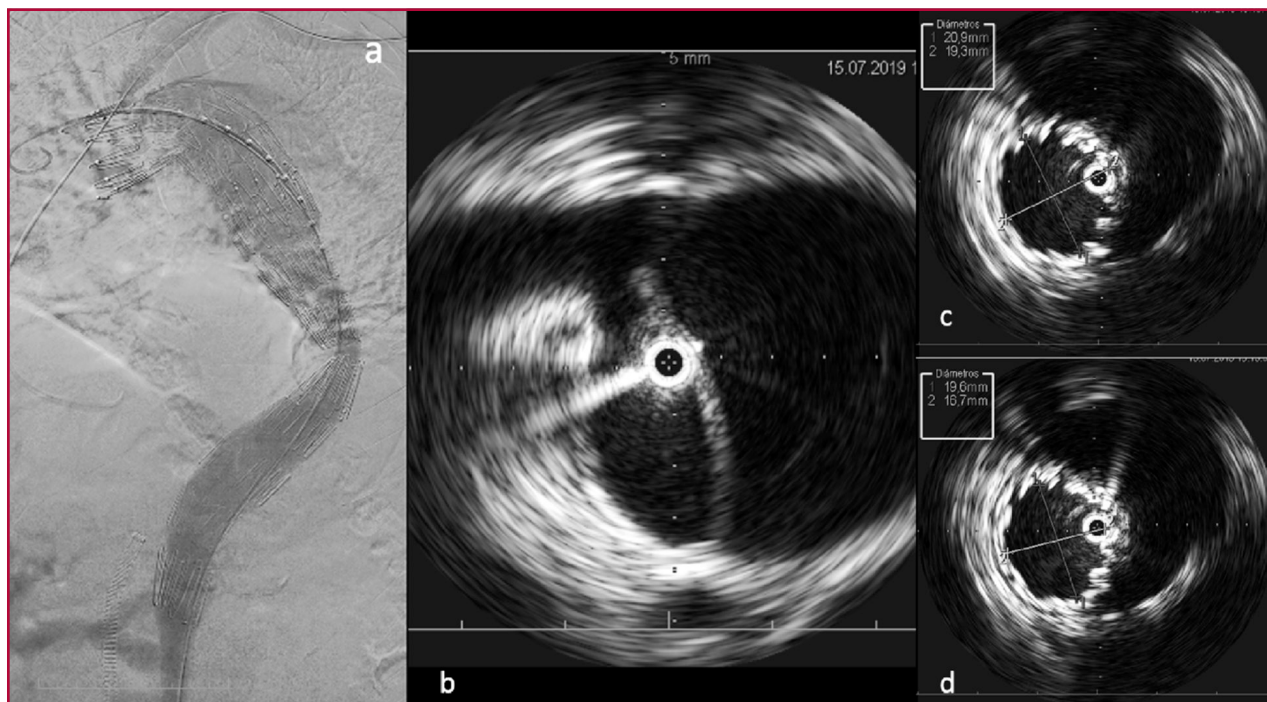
Intravascular ultrasound image. Final angiography showing the exclusion of false lumen in a patient with a type B aortic dissection (a). IVUS images show that the guidewire through which the stent-graft should be delivered is in the true lumen (b), and that the true lumen expands along several segments of the aorta after the stent-graft which occludes the entry orifice of the dissection is implanted (c-d).
